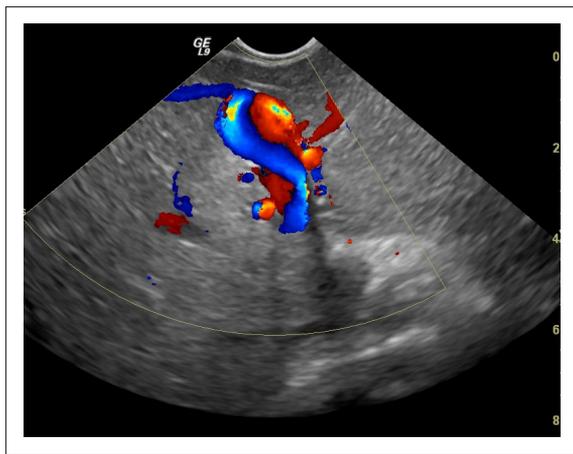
Doppler Sonography of the liver demonstrated flow within the dilated tubular structure consistent with blood vessel. The flow within it has two opposite directions showing in red (toward the transducer) and blue (away from the transducer).
